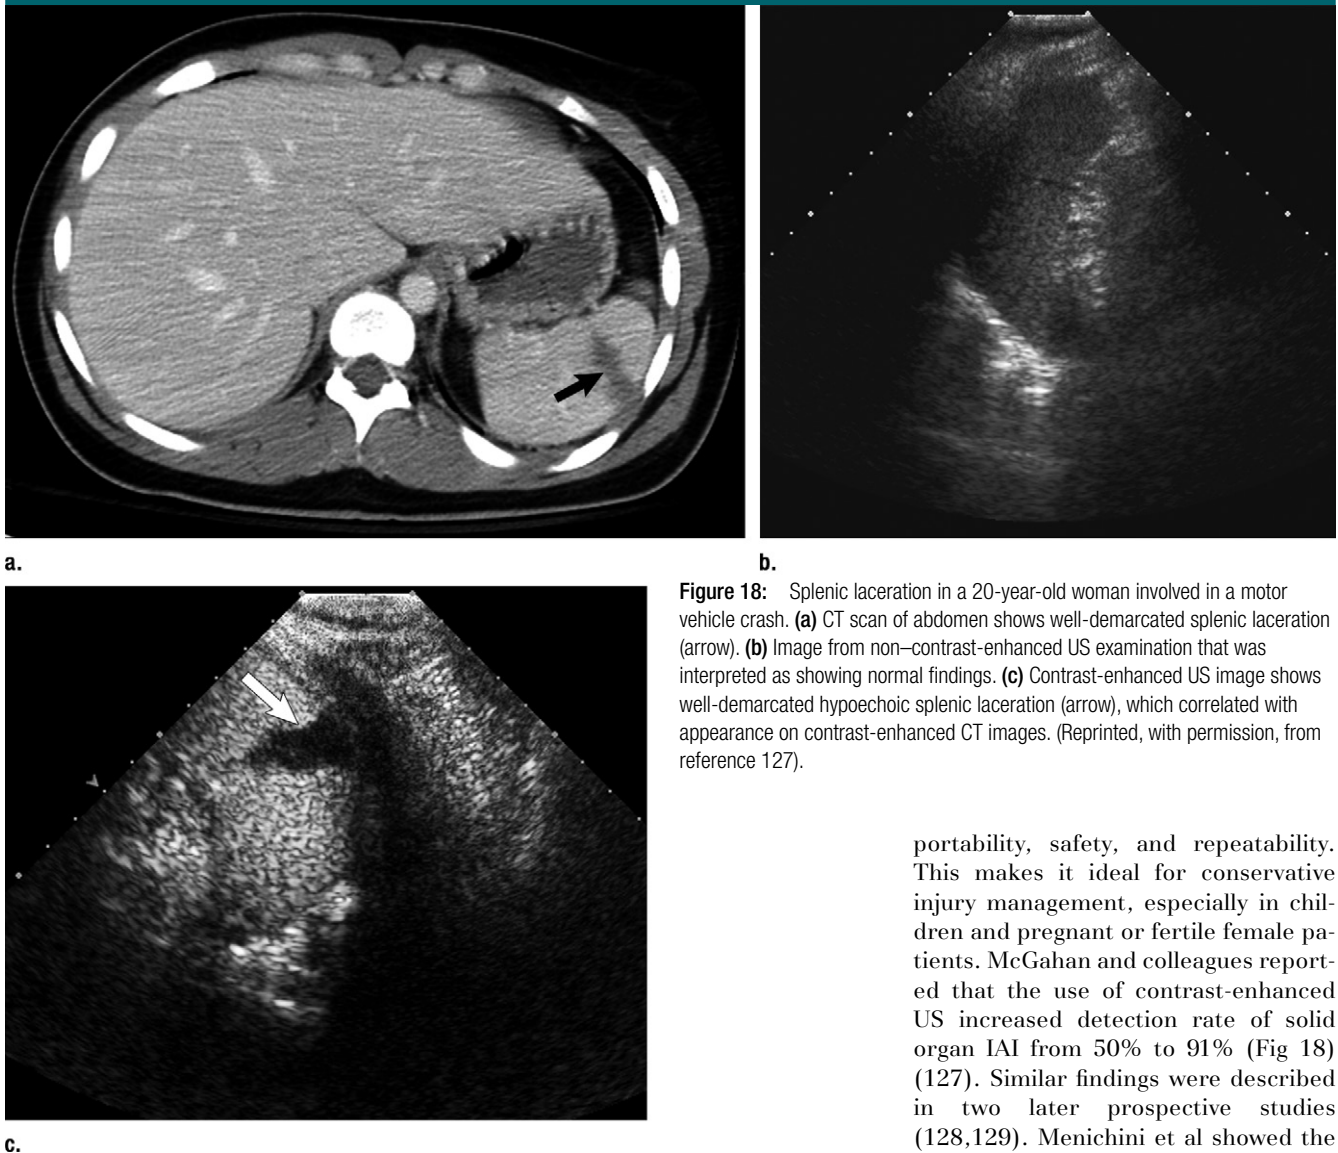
Splenic laceration in a 20-year-old woman involved in a motor vehicle crash. (a) CT scan of abdomen shows well-demarcated splenic laceration (arrow). (b) Image from non-contrast-enhanced US examination that was interpreted as showing normal findings. (c) Contrast-enhanced US image shows well-demarcated hypoechoic splenic laceration (arrow), which correlated with appearance on contrast-enhanced CT images. (Reprinted, with permission, from reference 127).
